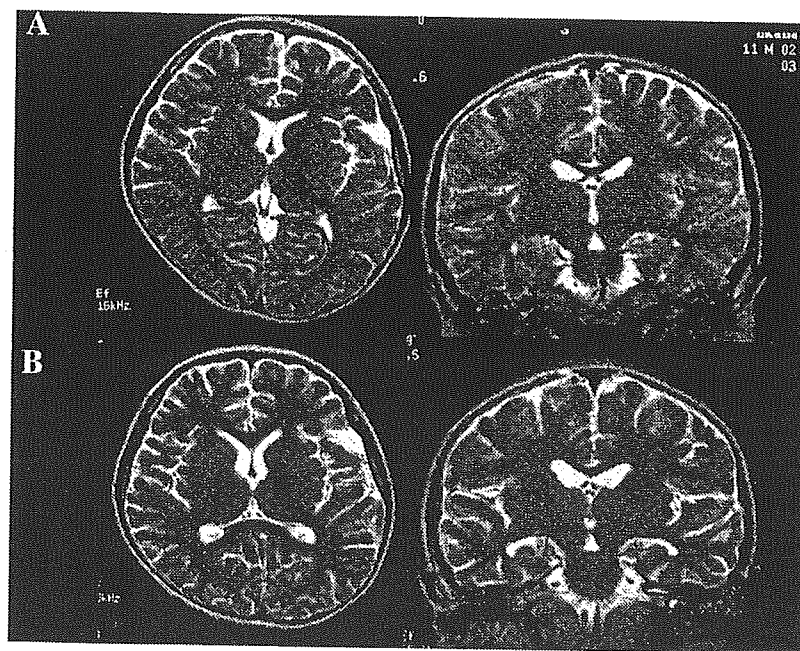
(A) Brain MRI T2-WI on admission showed no abnormality. (B) Brain MRI on day 36 showed mild atrophy of the hippocampus, amygdala, and cerebrum.
